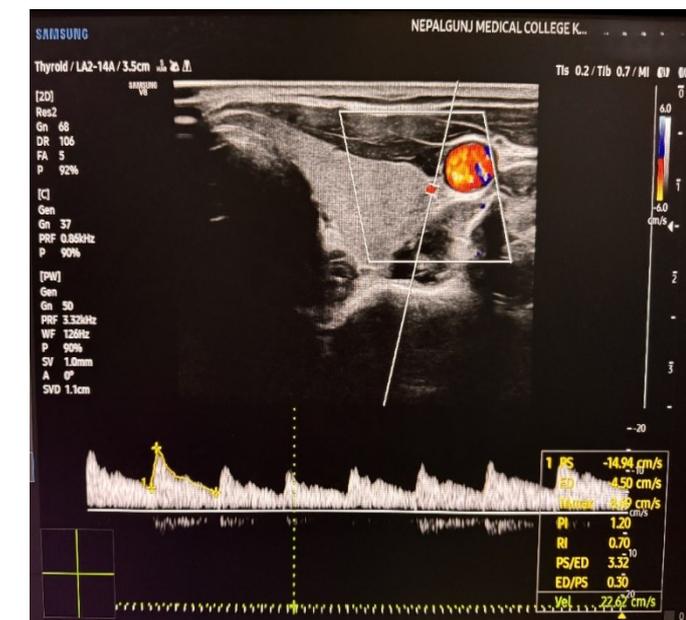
Spectral Doppler ultrasound of the inferior thyroid artery demonstrating a normal arterial waveform
